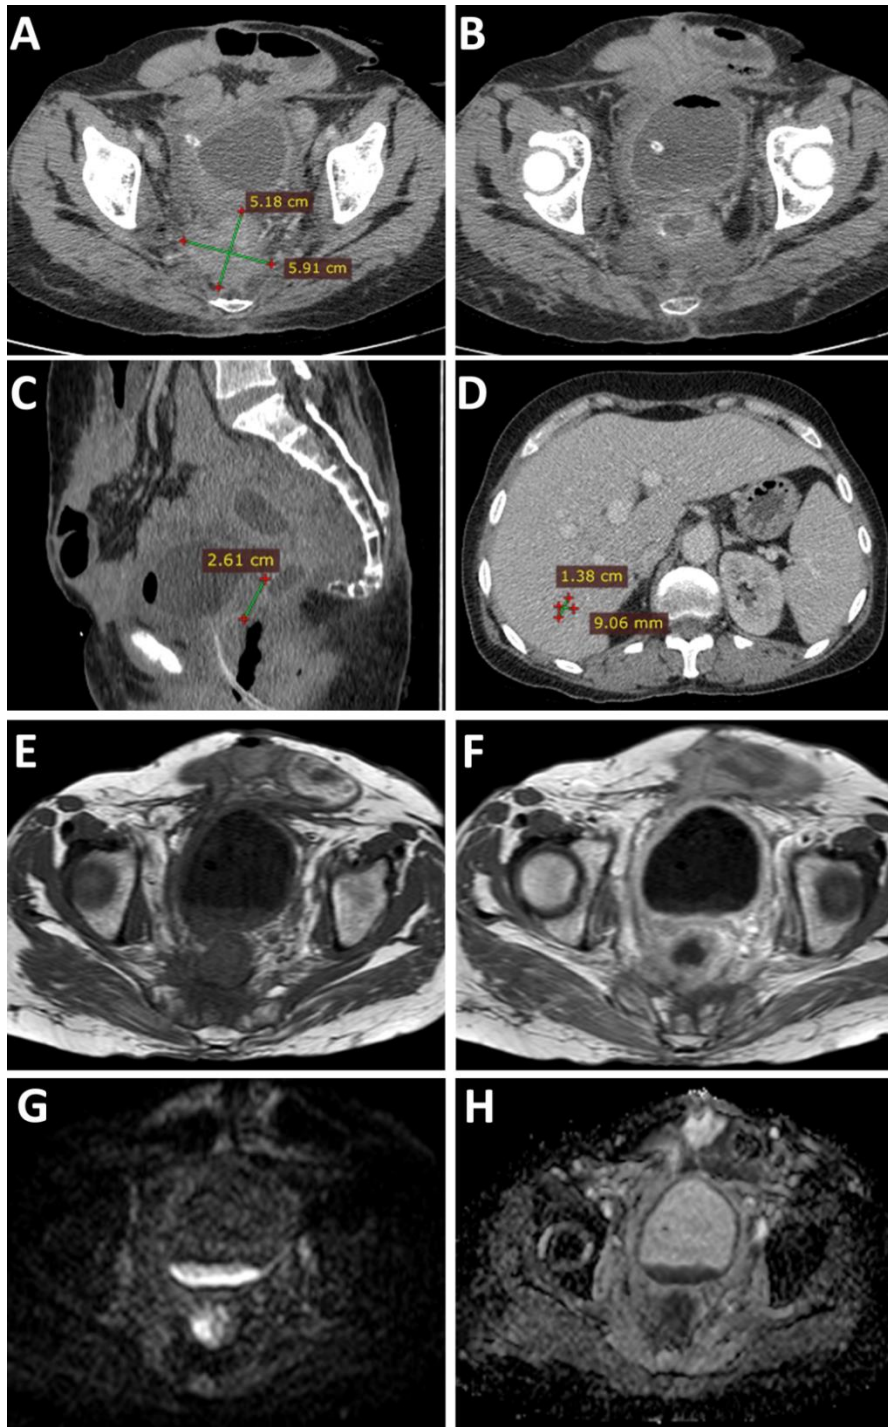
Case (4) CEA level was 45ng/ml, (A&B) axial post contrast CT cuts show diffuse irregular rectal wall thickening with pre-coccygeal enhanced soft tissue density mass lesion (C) sagittal reconstructed image shows infiltrated fat planes between the uterus and the rectum. (D) axial cuts CT abdomen porto-venous phase shows multiple well defined hypodense hepatic nodules seen in segment VII. (E&F) axial T1WI pre and post contrast show irregular wall thickening with post contrast enhancement at the anorectal junction (arrow). In DWI (G&H) there is diffusion restriction displaying high signal intensity on DWI (asterisk) and low signal intensity on its corresponding ADC map (arrow) denoting recurrence.
